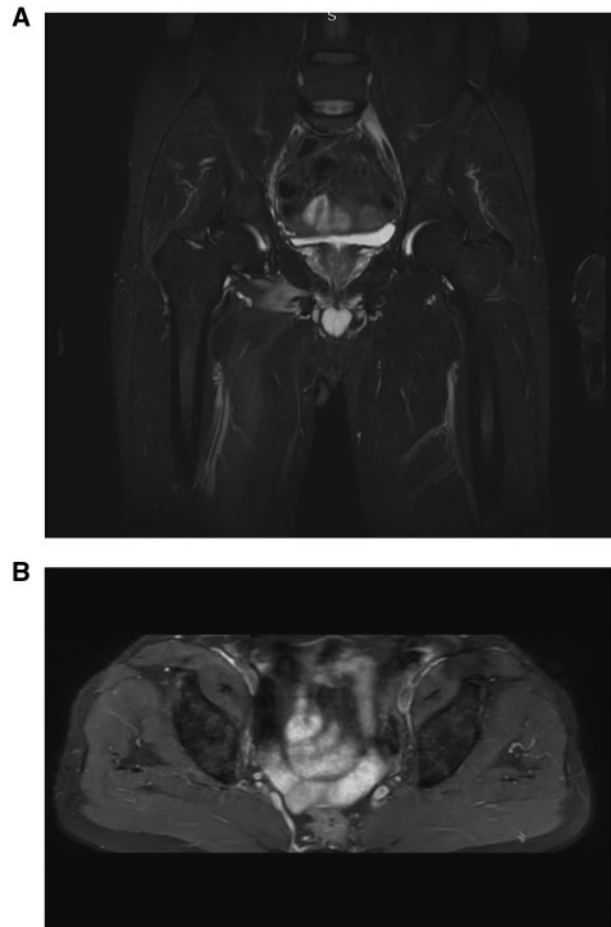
Updated MRI without evidence of cyst remanence.
